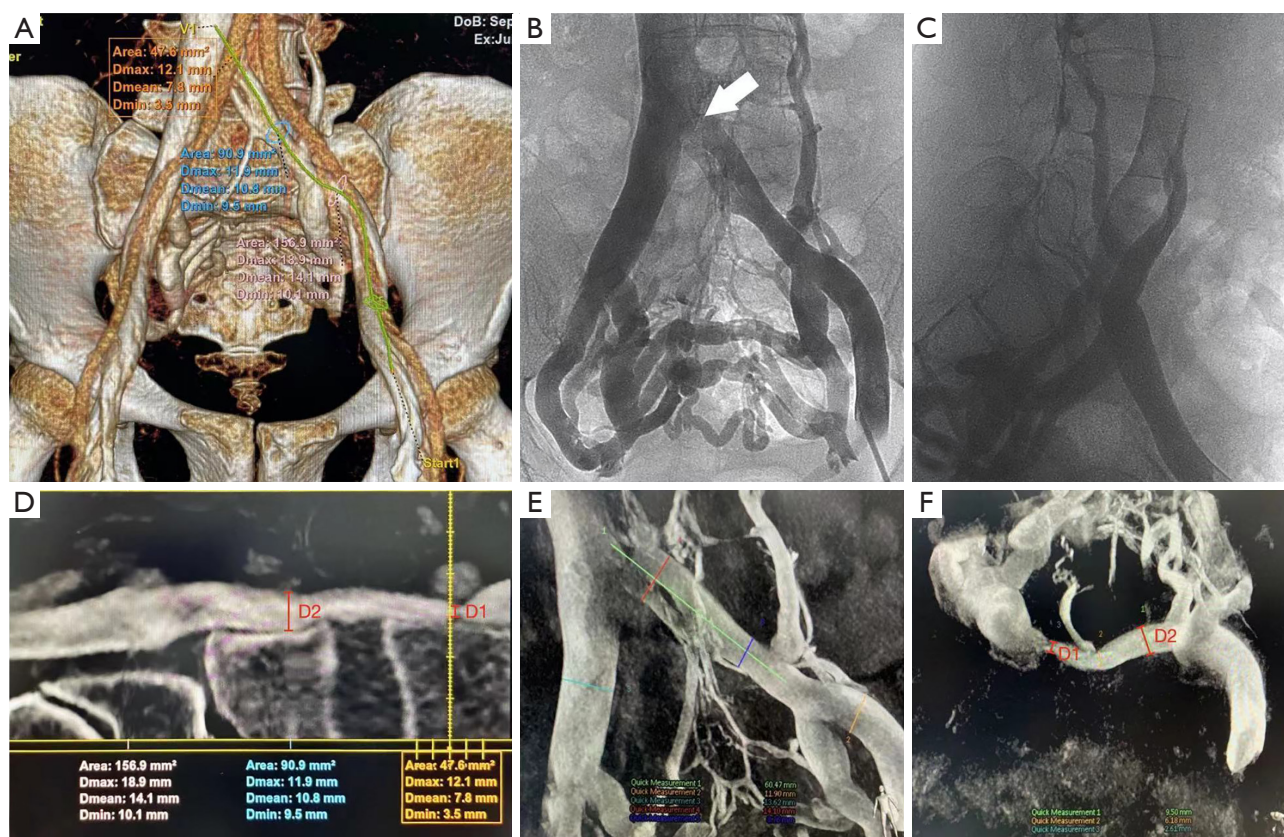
CTV and venographic images of a 53-year-old woman with IVCS. VR and centerline image reconstruction of iliac vein were performed (A,B). With the centerline image, the point of maximum iliac vein can be identified accurately. The degree of stenosis is determined by the following formula: $\text{Stenosis} = 100 - (100 \times D1/D2)$, where D1 is the minimum diameter at the point of maximum compression and D2 is the minimum diameter at the common iliac vein. Therefore, the degree of stenosis in this patient was calculated to be 63.2%. Intraoperative 3D venography was performed (C,E), the site of the maximum iliac vein compression by the iliac artery (white arrow) and plenty of pelvic collateral vessels were found. The iliac vein was reconstructed, and stenosis rate was calculated to be 72.5% (D,F). CTV, computed tomography venography; IVCS, iliac vein compression syndrome; VR, volume rendering.
